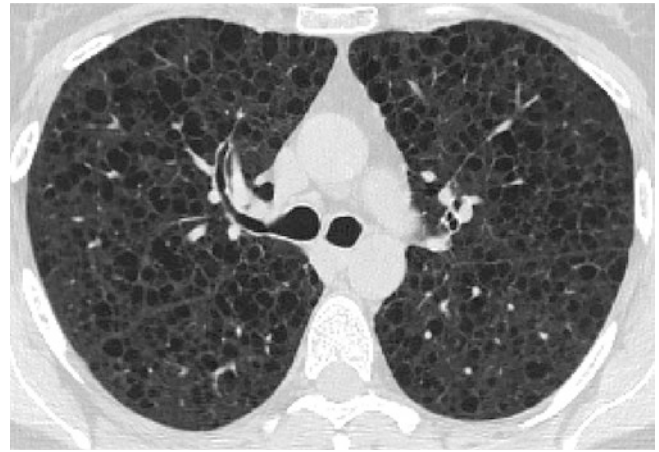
Transaxial chest CT in a patient with lymphangiomyomatosis showing diffuse thin-walled cysts
